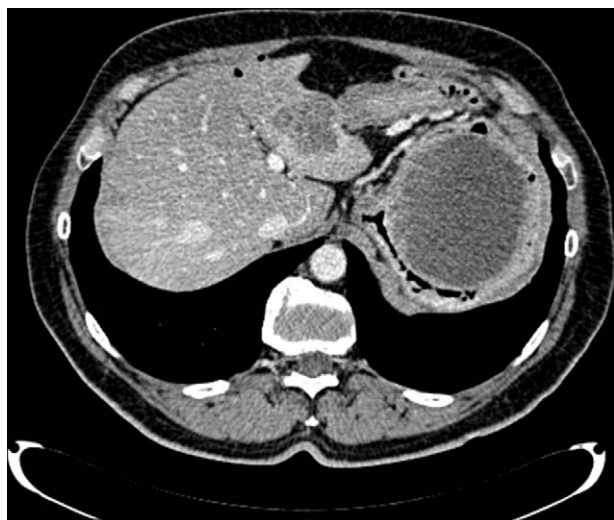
Abdominal computed tomography image prior to treatment with regorafenib (August 2015).
